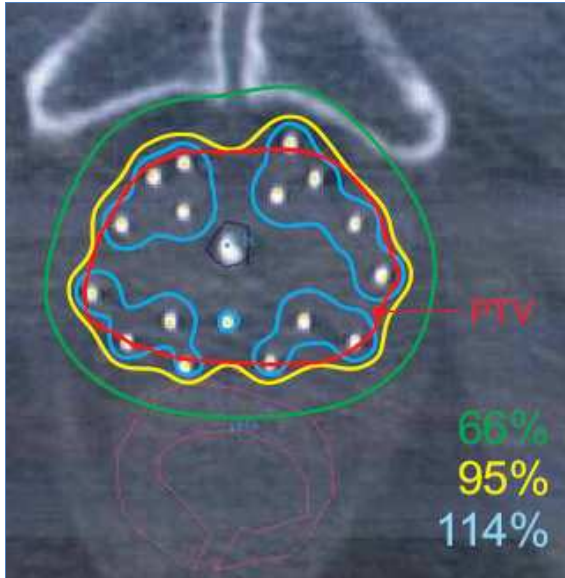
CT-scan image before brachytherapy treatment delivery with transperineally inserted temporary sealed-tip hollow catheters into the prostate gland. Red indicates planning target volume (PTV) and prostate; light blue, 114% isodose line; yellow and green, 95% and 66% isodose lines, respectively. Urethra=dark blue, Rectum=purple
